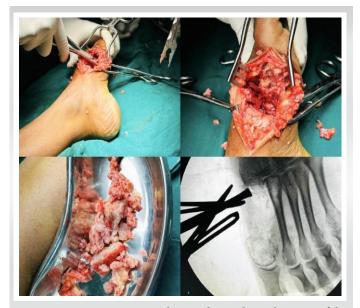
Intraoperative images showing the intralesional excision of the tumor with a radiograph depicting the complete excision.
